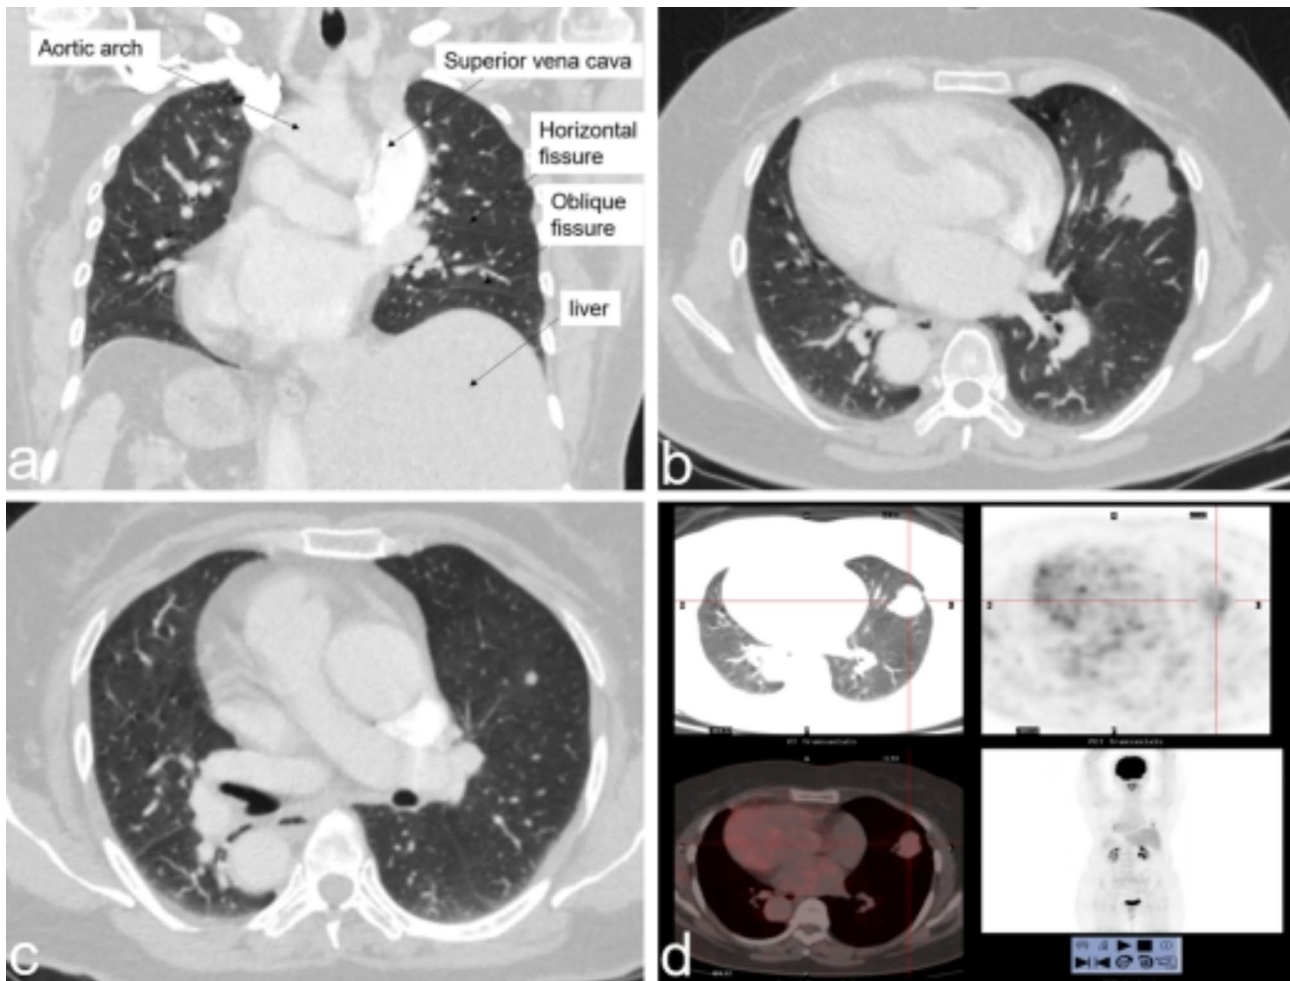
Radiological findings of the pulmonary tumor and thoracic anatomy of the patient (a) CT image in the coronal view reveals situs inversus totalis. (b) Chest CT shows an irregularly shaped solid tumor shadow (measuring 35×25 mm in diameter) in the peripheral pleural area of the left middle lobe. (c) Chest CT shows a 5-mm solid nodule in the left upper lobe attached to the interlobar pleura. (d) 18 F-FDG-PET shows a hot spot in the tumor. (CT, computed tomography; 18 F-FDG-PET, fluorine 18 fluorodeoxyglucose-positron emission tomography)
